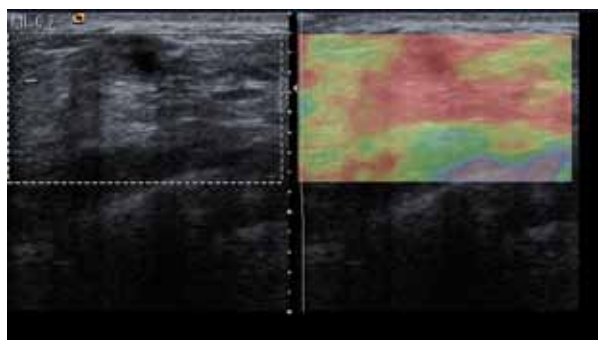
Galactocele in a 29 Year-old-woman with Heterogenous Internal Echotexture with Posterior Acoustic Enhancement. Though the margin of the lesion is not clearly visible, correlating clinically it was defined as benign from 2D sonography. On UE there was no strain over the entire hypoechoic lesion or in the surrounding area. Both the lesion and its surrounding area are red (Score 5)
